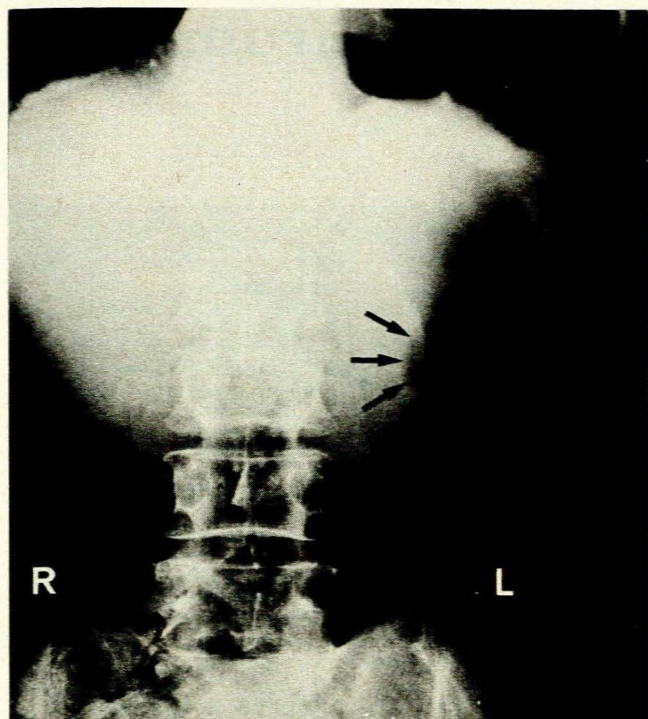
Plain abdominal radiograph taken in the anteroposterior position. The stomach is dilated with air and the ulcer is seen as an outpouching in the middle third of the lesser curvature of the stomach. The arrows are outside the stomach and delineate the peritoneal surface of the ulcer crater.
